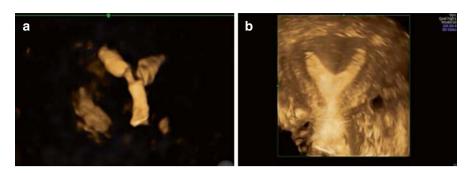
(a) Incomplete septate uterus displayed in contrast mode. (b) Incomplete septate uterus shown in the 3D ultrasound coronal plane
